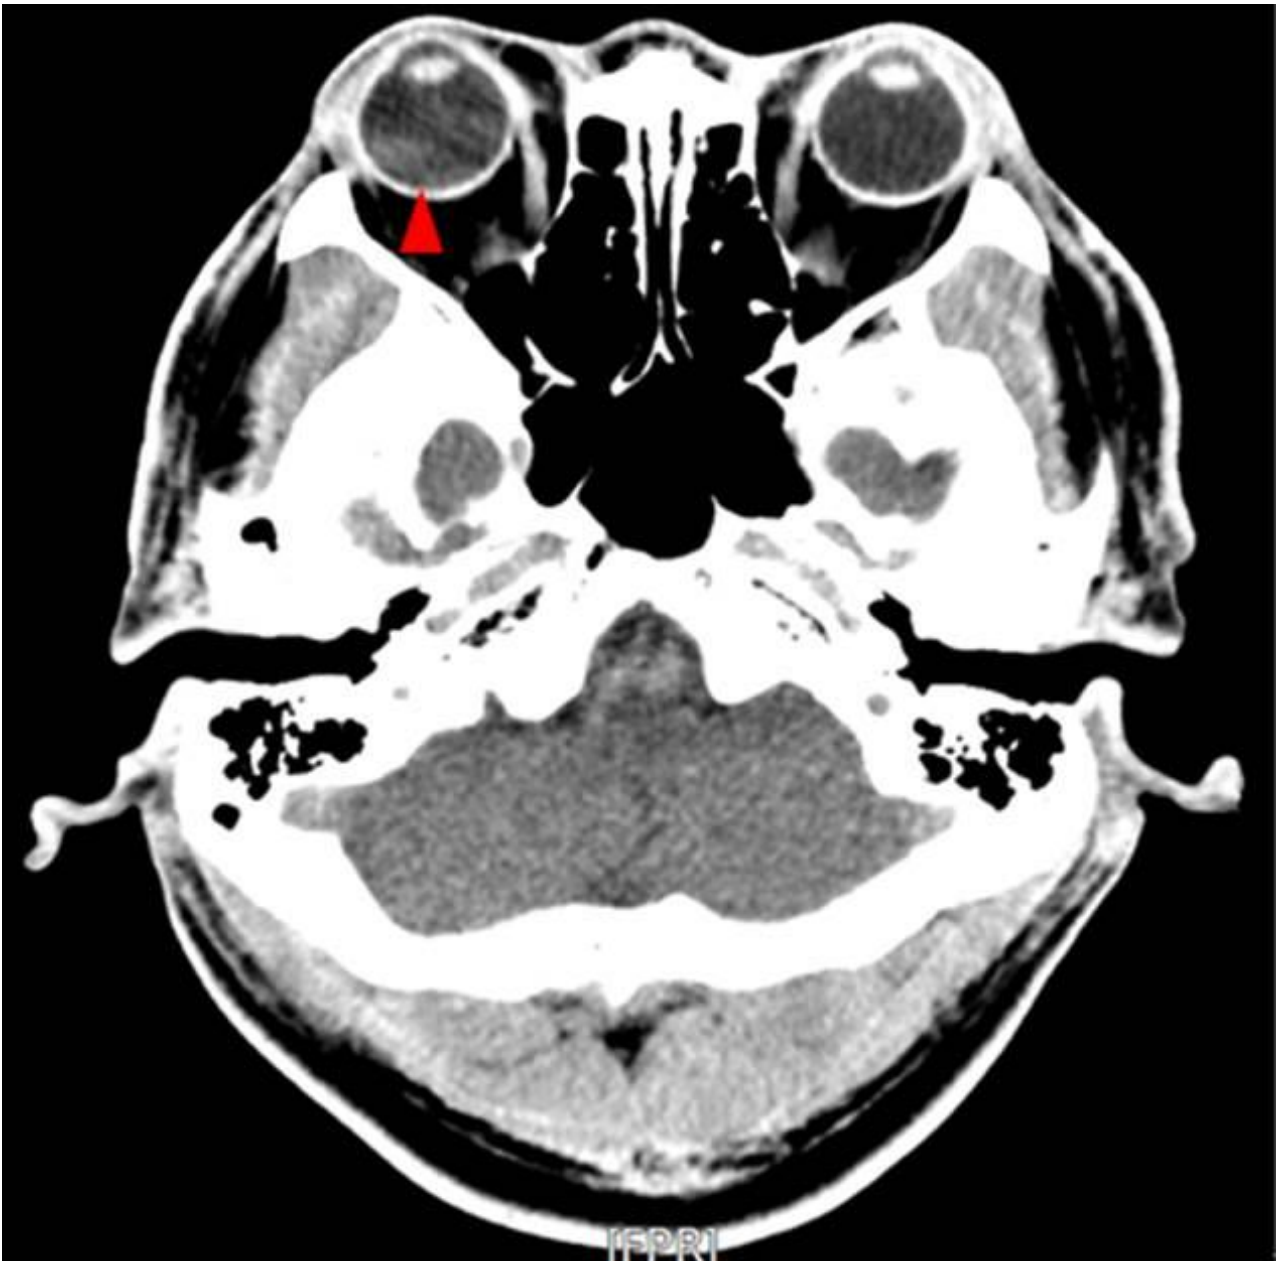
CT finding was suggestive of retinal hemorrhage manifested by a retinal nodularity (within 1 day).
